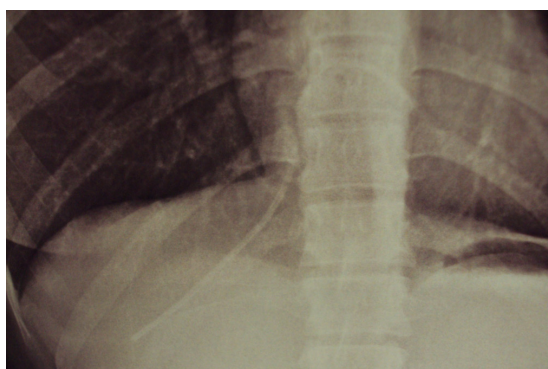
Chest X-ray showing the fractured catheter embolized in the inferior vena cava.
